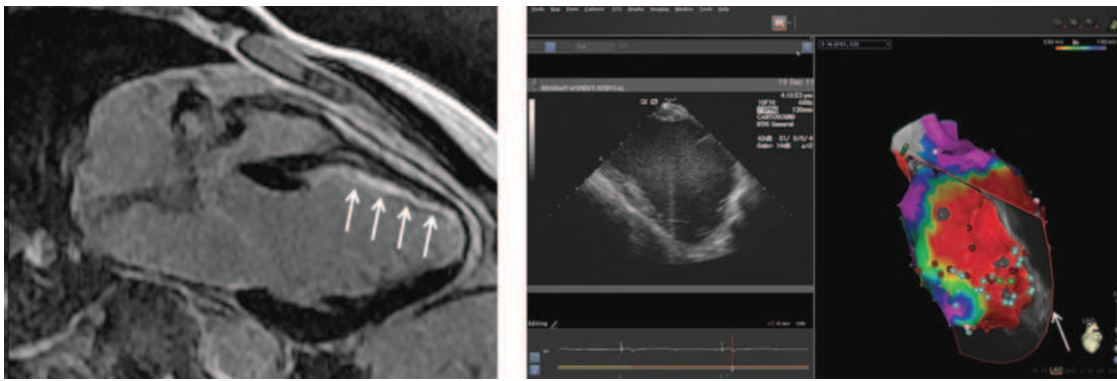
Imaging studies of the left ventricle (LV) used to assist ablation for ventricular tachycardia (VT). *Left panel* is a magnetic resonance image of a longitudinal section demonstrating thinning of the anterior wall and late gadolinium enhancement in a subendocardial scar (white arrows). The *middle panel* shows a two-dimensional image of the LV in long axis corresponding to the sector through the mid-LV (arrow in figure on right panel) obtained by an intracardiac echocardiography probe positioned in the right ventricle. An electroanatomic three-dimensional map of the LV in the left anterior oblique projection is displayed in the *right panel*. The purple areas depict areas of normal voltage (>1.5 mV). Blue, green, and yellow represent progressively lower voltages, with the red areas indicating scar (<0.5 mV). Channels of viable myocardium with slow conduction within the scar are identified with the light blue dots. Areas of ablation delivered to regions involved in reentrant VT are indicated by maroon dots.
